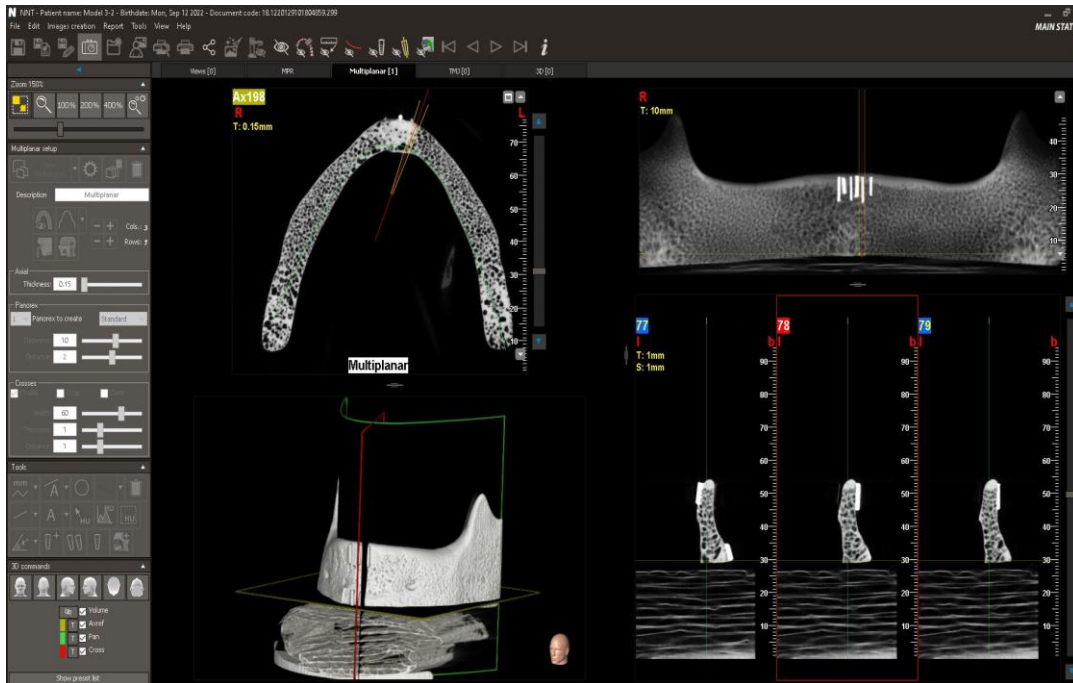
CBCT MPR presentation using NNT software*
